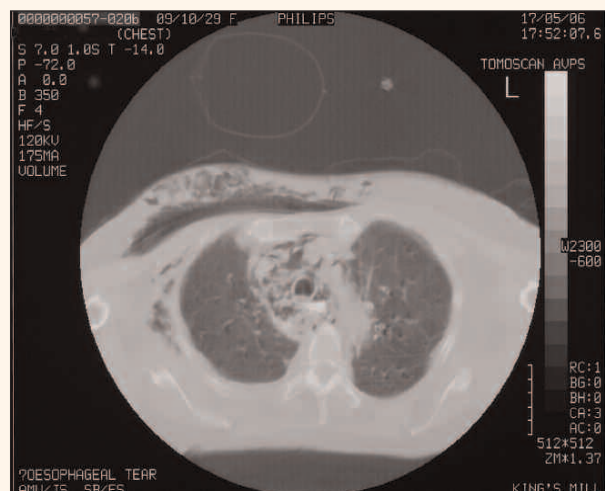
CT scan of the thorax.
